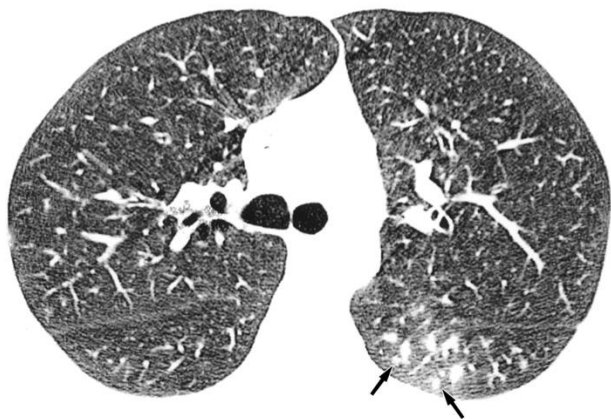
Imagery work up ----- > [HR] CT scan
